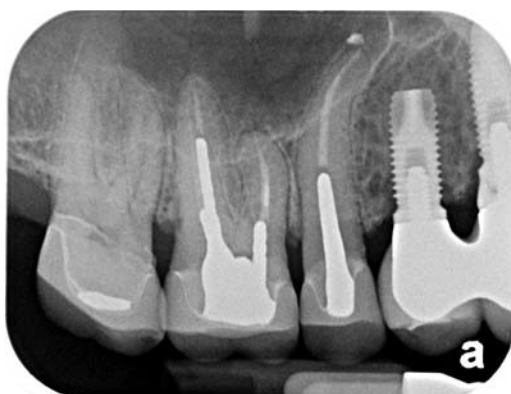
Radiograph showing the translucent effect in radiography of the lithium disilicate crowns. All underlying tooth structure can be visualized.
